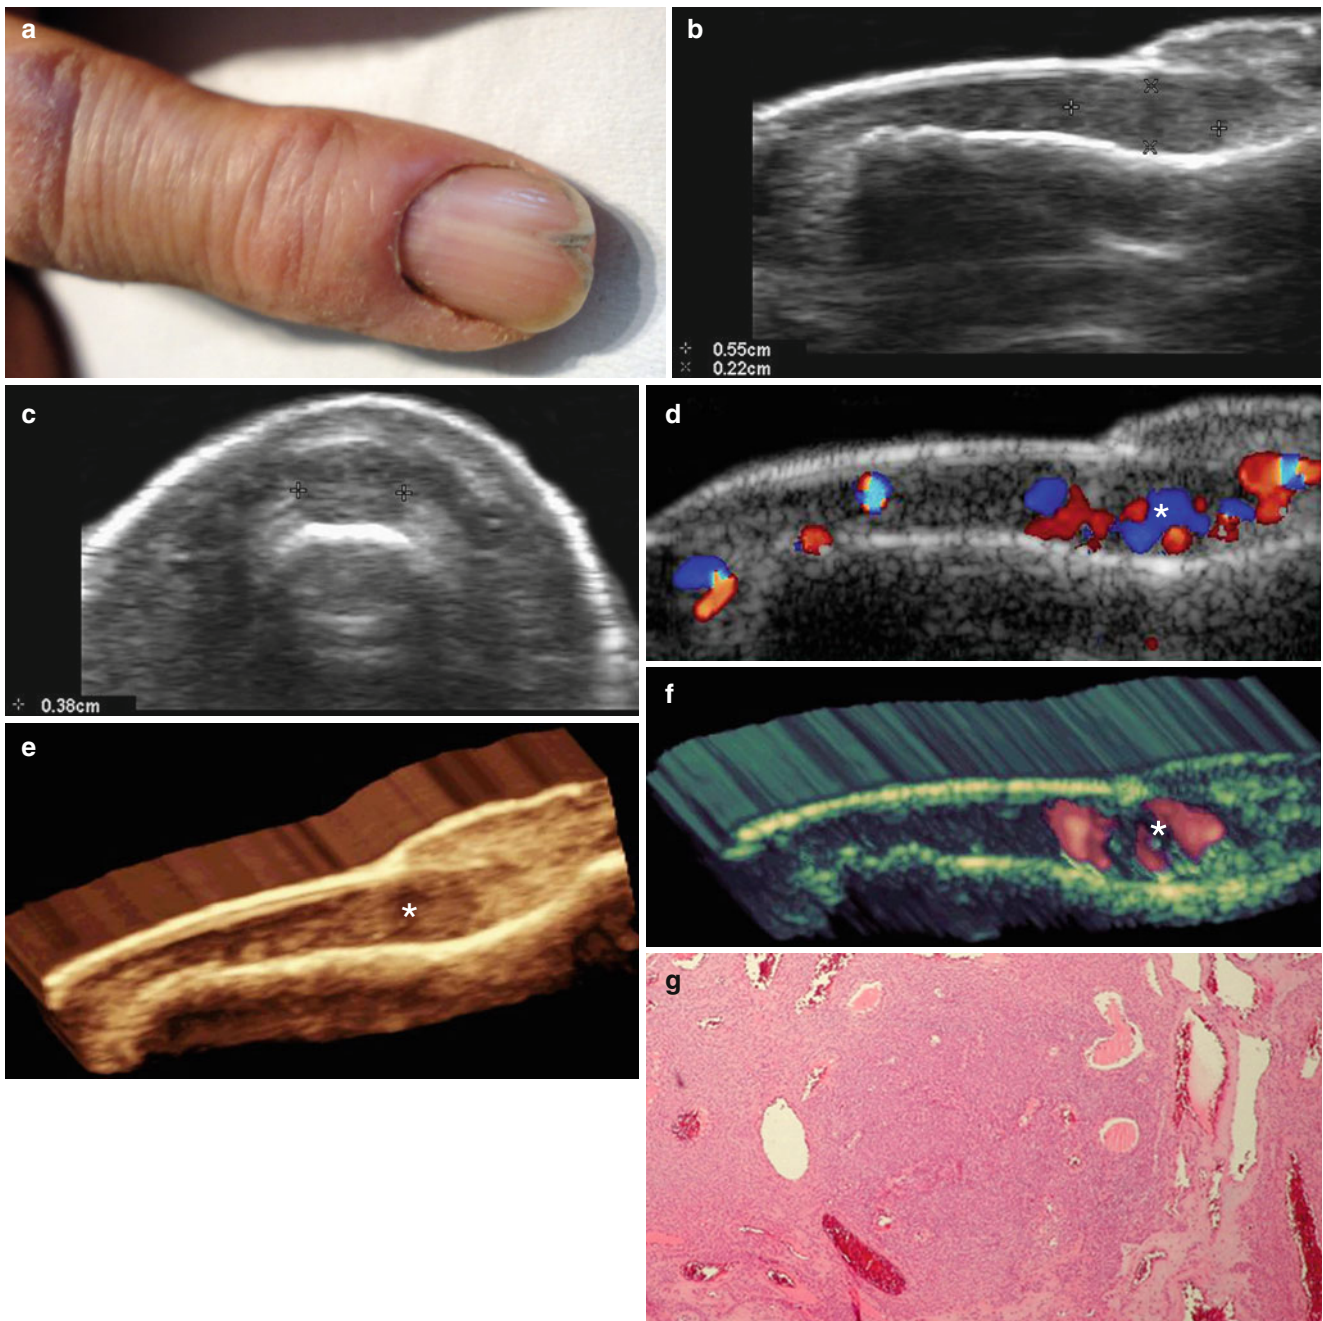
(a–g) Glomus tumor of the nail. (a) Clinical dystrophy of the nail of the left index finger. (b) Grey scale ultrasound (longitudinal view) shows 0.55×0.22 cm (long and depth axis, respectively), well-defined, oval -shaped, hypoechoic nodule in the proximal nail bed. Notice the slight upward displacement of the nail plates and the remodeling of the bony margin of the distal phalanx. (c) Grey scale ultrasound
